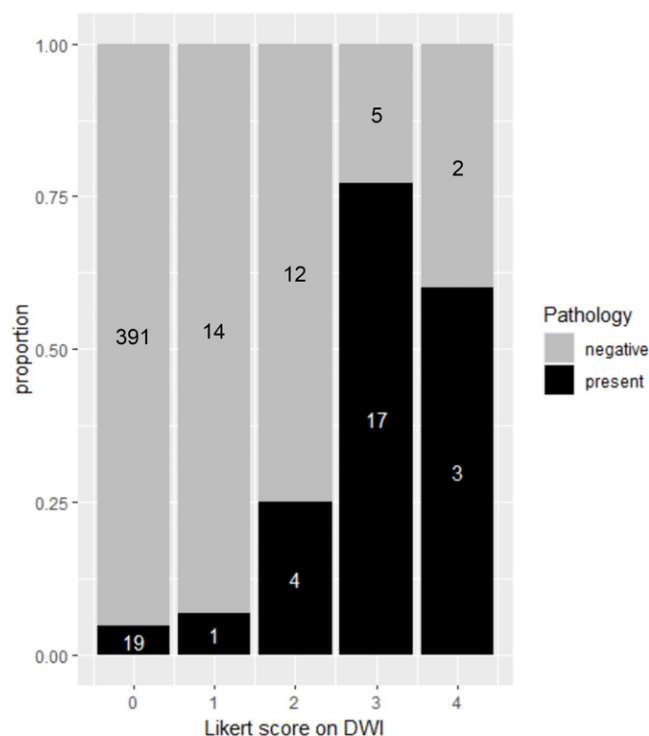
Stacked bar plot shows the per-quadrant distribution of extramural venous invasion and tumor deposit as assessed with the diffusion-weighted imaging (DWI) five-point Likert scale and whole-mount pathology. Gray area of the stacked bar represents quadrants with nonviable cells at pathology, and the black area of the stacked bars represents quadrants with viable cells at pathology. A total of 410 quadrants were assigned a Likert score of 0 (unlikely viable), 15 quadrants were assigned a Likert score of 1 (less likely viable), 16 quadrants were assigned a Likert score of 2 (possibly viable), 22 quadrants were assigned a Likert score of 3 (suspicious viable), and five quadrants were assigned a Likert score of 4 (consistent with viable).
